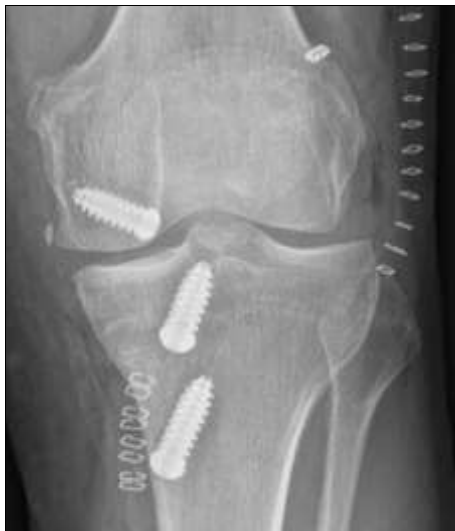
Radiograph showing a widened medial joint space and lateral tibial translation.
